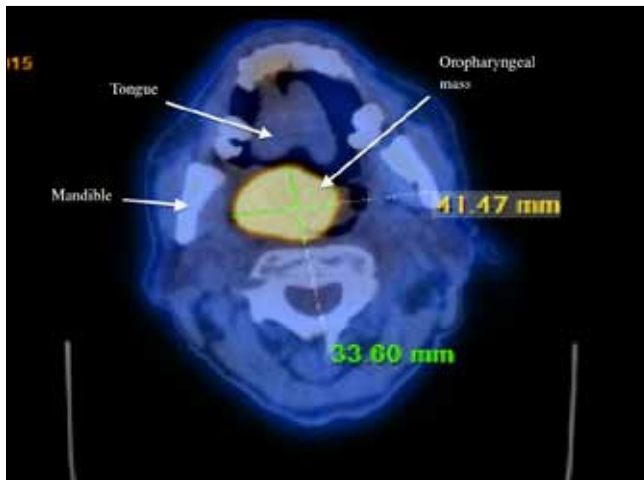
Axial PET CT image of mass in the oropharynx
